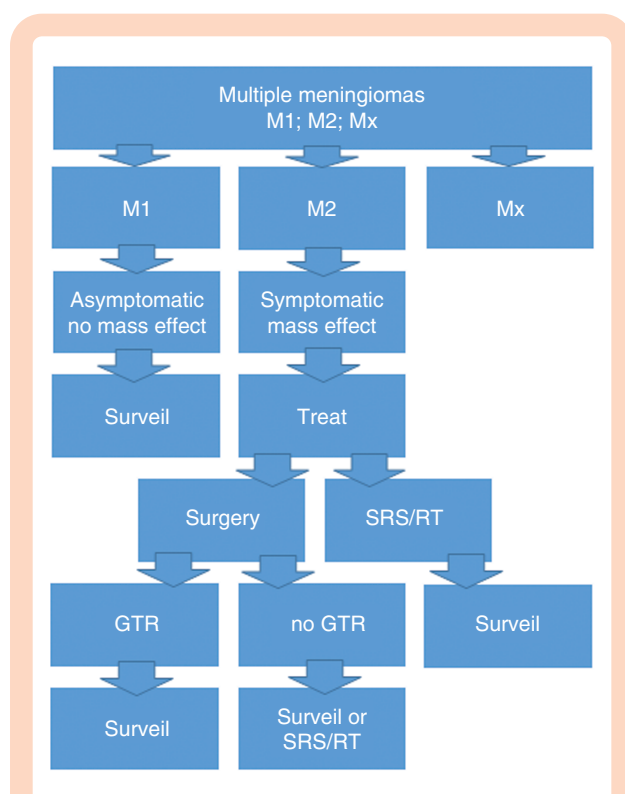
Management recommendations for multiple meningiomas. Surveillance: annual MRI scans for 5 years, thereafter interval can be doubled. GTR, gross total resection; RT, fractionated radiotherapy; SRS, stereotactic radiosurgery.
